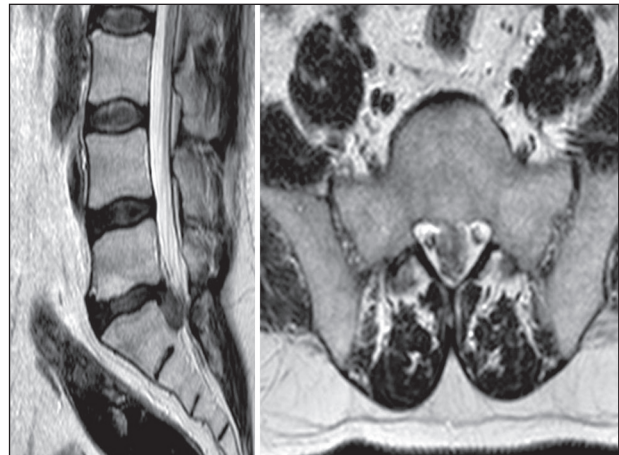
Pre-operative lumbar magnetic resonance imaging (MRI) of 55-year-old male with sexual dysfunction and L5-S1 lumbar disc herniation
